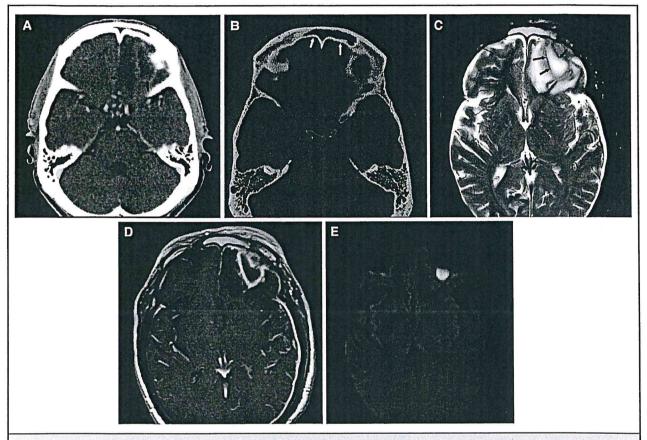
Adult patient with several weeks of sinusitis, now with severe headache, seizures, and altered mental status. Bacterial frontal sinusitis with intracranial abscess. A, Axial CECT shows a peripherally enhancing left frontal intra-axial mass (arrows) with surrounding vasogenic edema (short arrows). Note opacified frontal sinus. B, Bone algorithm CT confirms opacified frontal sinus, but the posterior wall is intact (arrows). The infection can extend from the sinus intracranially presumably through venous channels, without destroying the posterior wall. C, Axial T2-W FS image shows boggy edema in the left forehead and the completely opacified frontal sinus, filled with hyperintense debris and pus. The abscess has a low SI rim (arrows), a characteristic appearance for brain abscess on T2 images. D, Axial T1-W Gd-enhanced image shows the peripheral enhancement of the abscess capsule, the central debris and pus, and surrounding vasogenic edema. There is diffuse thin non-nodular dural enhancement (arrows) of the entire left cerebral hemisphere, likely a combination of meningeal edema and possibly subdural pus. E, On this diffusion image notice the markedly restricted diffusion in the abscess (arrows), a characteristic of brain abscess. There is artifact at the posterior frontal sinus wall and the frontal lobe, a limitation of diffusion imaging at any bone-brain interface.
